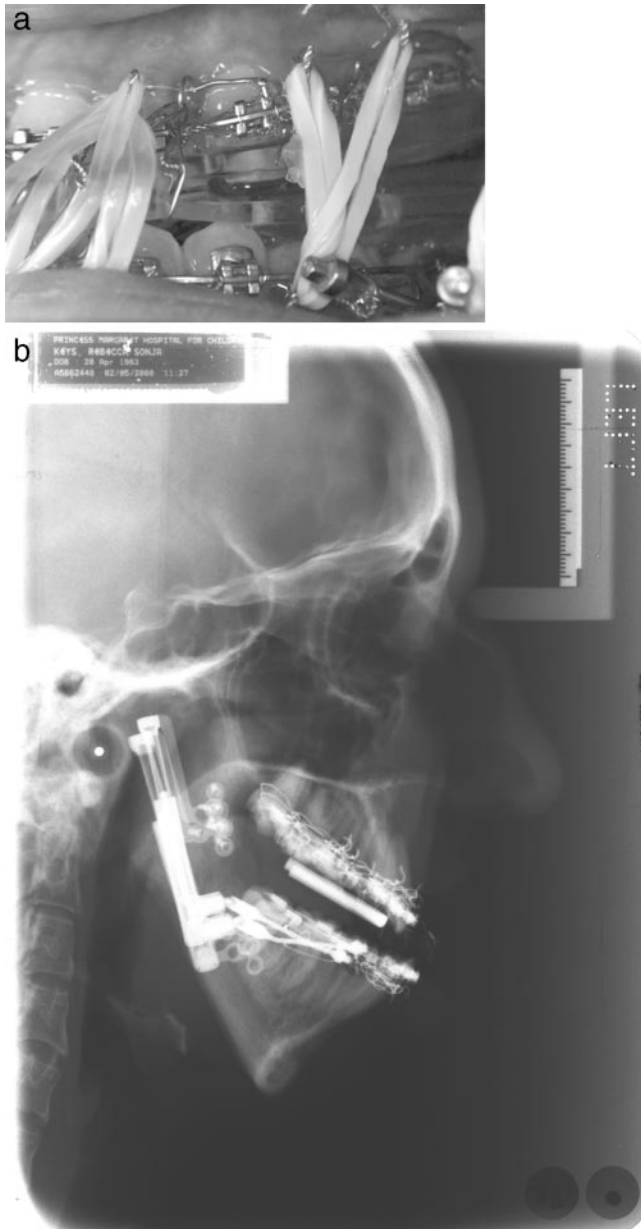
(a) Intraoral view of splint and elastic traction. Note progressive reduction in height of splint from molar to incisal region. (b) Progress lateral cephalometric radiograph after anticlockwise rotation of mandibular body.
